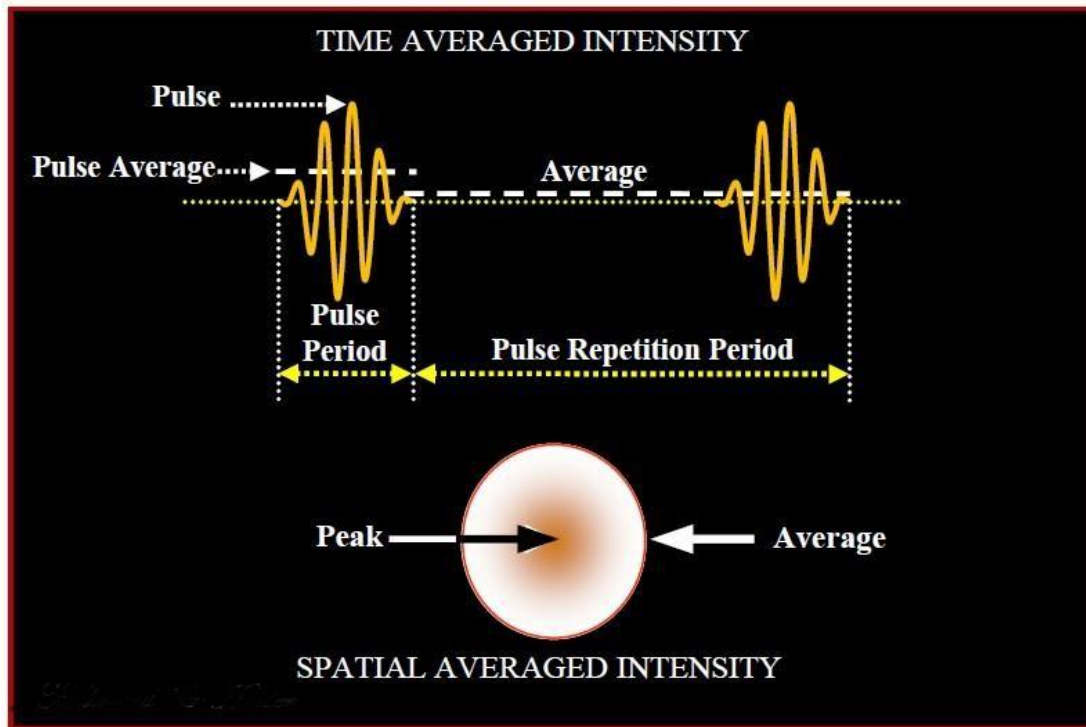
Temporal and Spatial Characteristics of Ultrasound Pulses That Affect Intensity Values.
